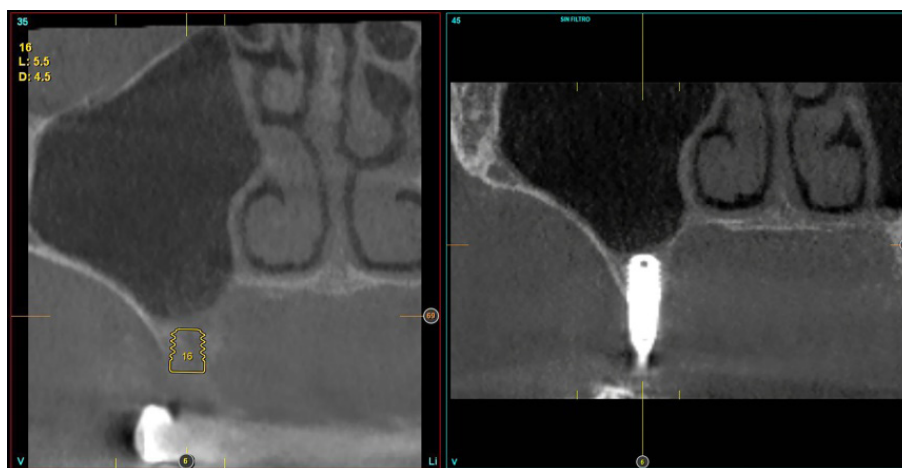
CT before and after in the follow-up of 6 month after the implant insertion and the immediate loading.
